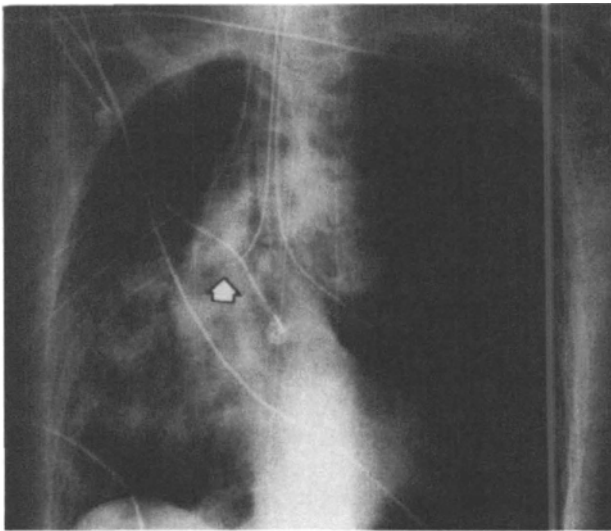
FIGURE Chest x-ray. A double lumen tube is in place, with the bronchial orifice in the left mainstem bronchus. The arrow indicates the position of the bronchial blocker as it passes through the tracheal lumen of the tube into the right upper lobe bronchus.
